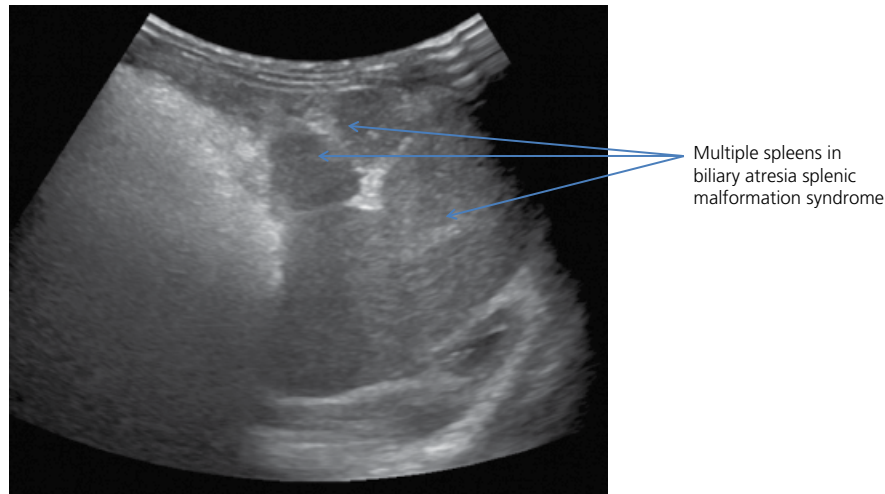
Ultrasound scan of a child with biliary atresia splenic malformation syndrome which accounts for 10–20% of cases of biliary atresia. The ultrasound demonstrates small multiple spleens.
